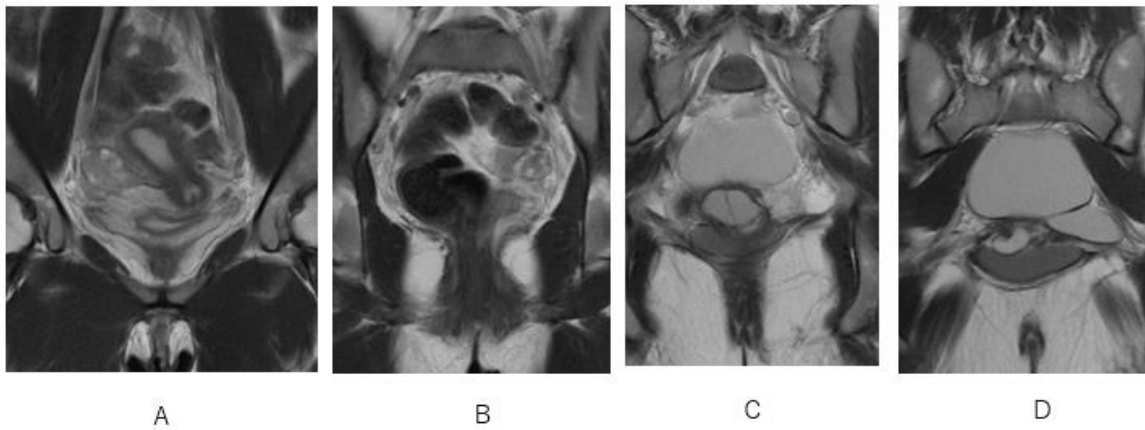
A multi-cystic lesion (C, D) situating behind uterus (A) and rectum (B) is depicted on coronal MRI with T2WI.
